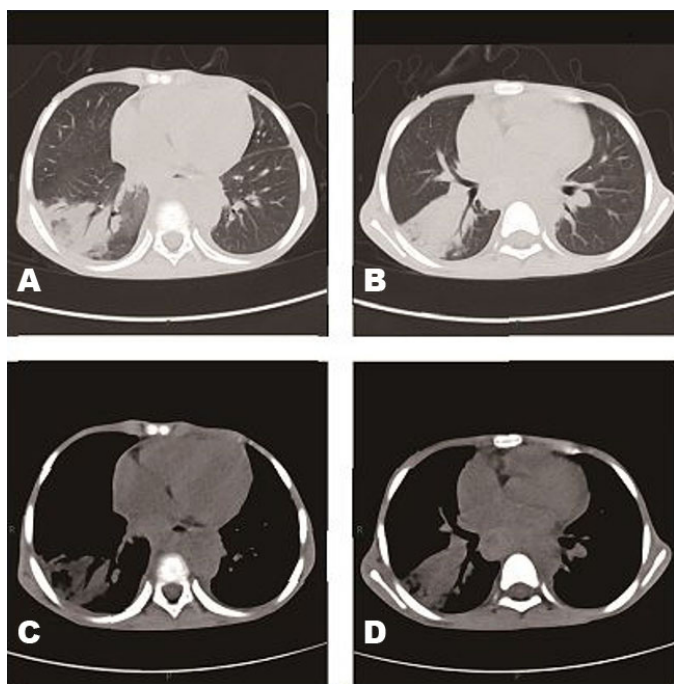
Computed tomography images of the patient from August 22, 2023. Images (A) and (B) represent lung windows, while (C) and (D) correspond to mediastinal windows. A newly identified nodule is observed in the left upper lobe, and a newly detected large area of consolidation is present in the right lower lobe. The chest CT of the patient indicates the presence of a severe pulmonary infection.
